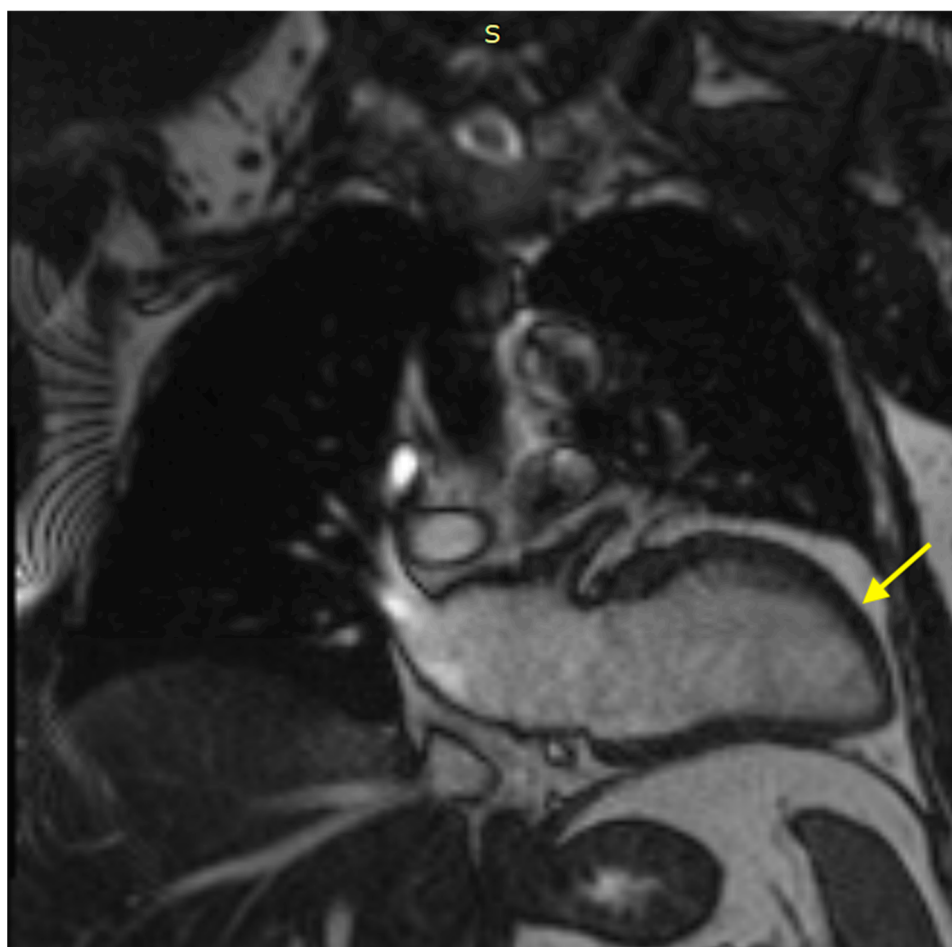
Cardiac MRI in the coronal plane with a large field of view, demonstrating abnormal leftward displacement of the cardiac silhouette within the left hemithorax (yellow arrow). .
